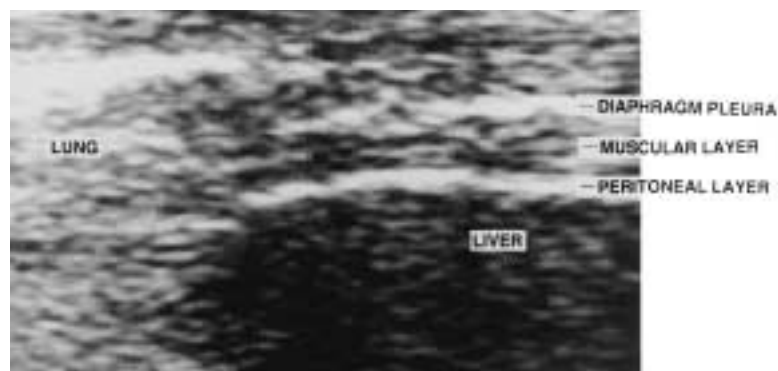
Ultrasound image of the diaphragm in the zone of apposition in a healthy individual. The diaphragm is identified as the structure bounded by the pleura and peritoneum.
